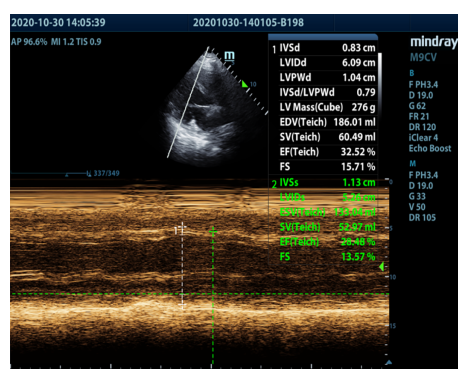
Echocardiography on admission. Left ventricular enlargement and left ventricular systolic function was significantly reduced. The ejection fraction was 28.48%.
